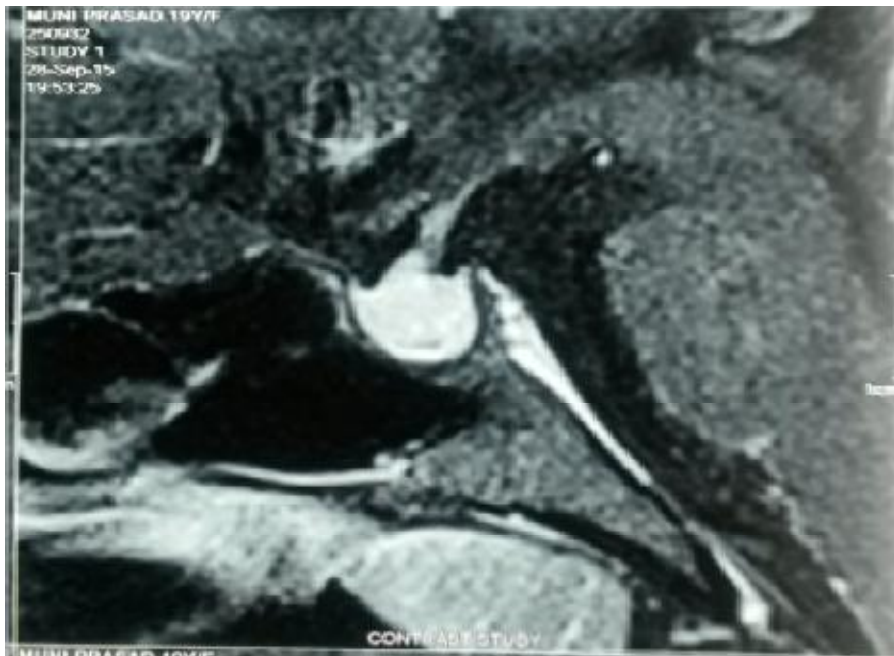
MRI pituitary at presentation T1W1 pre (a, b) and post contrast (c, d) images in sagittal and coronal sections
